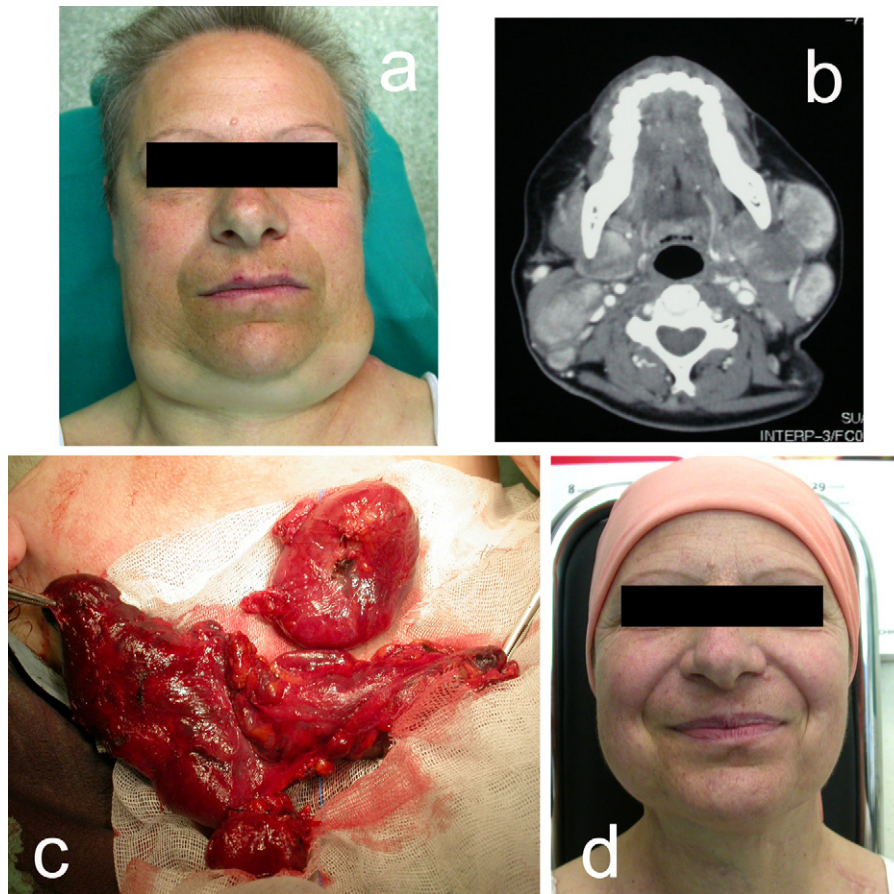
Clinical features of systemic amyloidosis with massive cervical involvement: (a) on physical pre-operative examination, gross adenopathy extending bilaterally from mastoids to clavicles, mainly affecting the submandibular lymph nodes; (b) CT scan with medium contrast, showing inhomogeneous enhancement of the masses; (c) intra-operative view; (d) 2-year-post-operative view.
